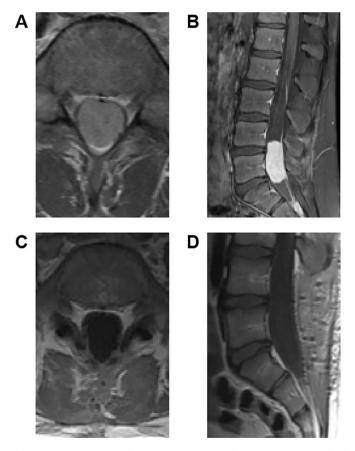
Case 2: 14-year-old male. Coronal (A) and sagittal (B) T1-weighted gadolinium contrast-enhanced images showing two intradural lesions adjacent to L5 and S2. T1-weighted coronal (C) and sagittal (D) images with gadolinium contrast enhancement obtained seven weeks after surgery showed complete excision of both lesions.
